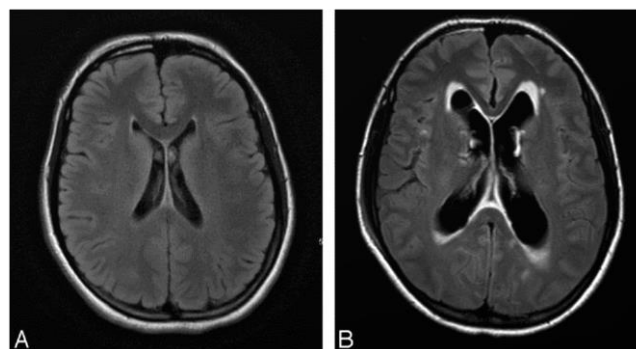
Axial fluid-attenuated inversion recovery MR images (A) 14 days before GKR (B) 36 Weeks post-GKR image. Ventriculomegaly is extended to third and fourth ventricle. Flow of CSF across ependymal layer of cells is shown in Figure 4B.
